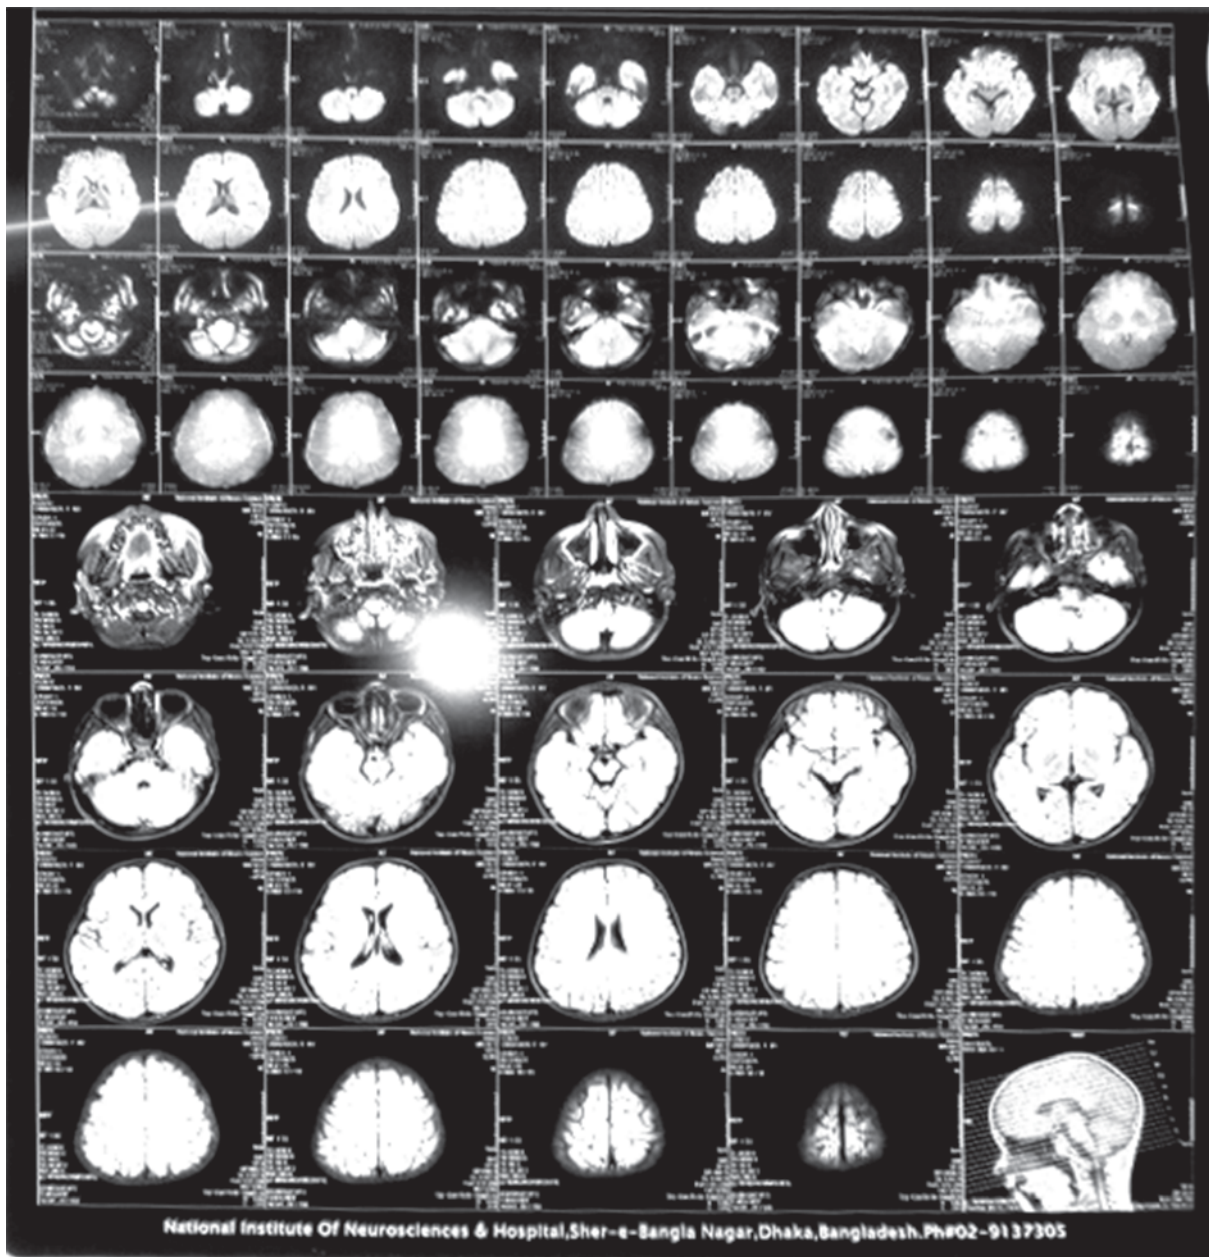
MRI of Brain showed diffuse T2WI and FLAIR hyperintense areas seen in the white matter region sparing the subcortical U fiber
